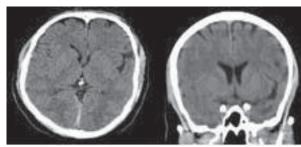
Second CT done after 48 hours showing complete resolution of the acute subdural hematoma.
